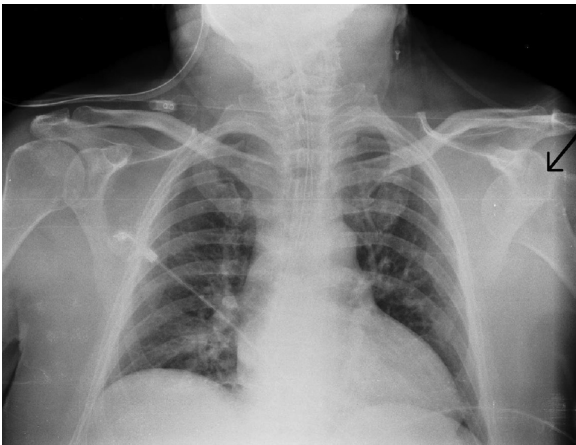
Chest X-ray performed in intensive care unit showing anterior dislocation with fracture of the lesser tuberosity (arrow).
